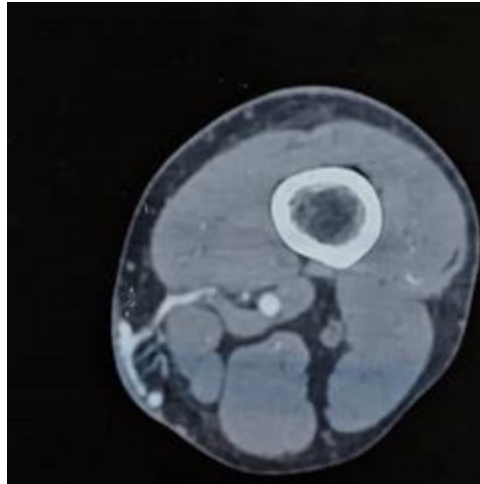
Angio-MRI of the AVM
